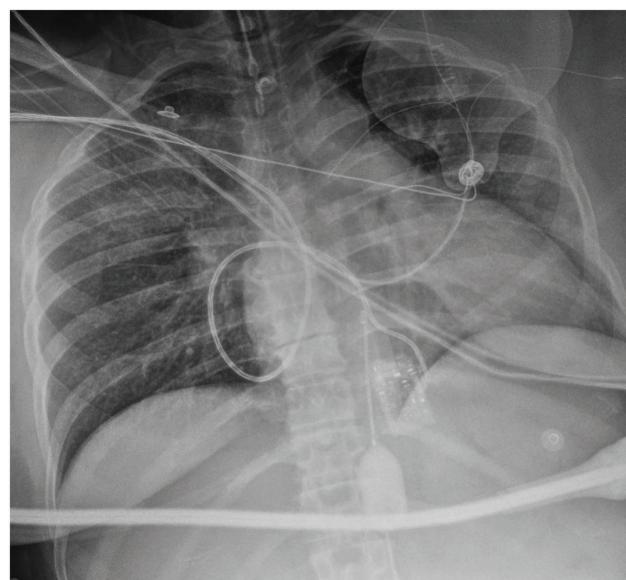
Chest X-ray immediately after balloon inflation.
